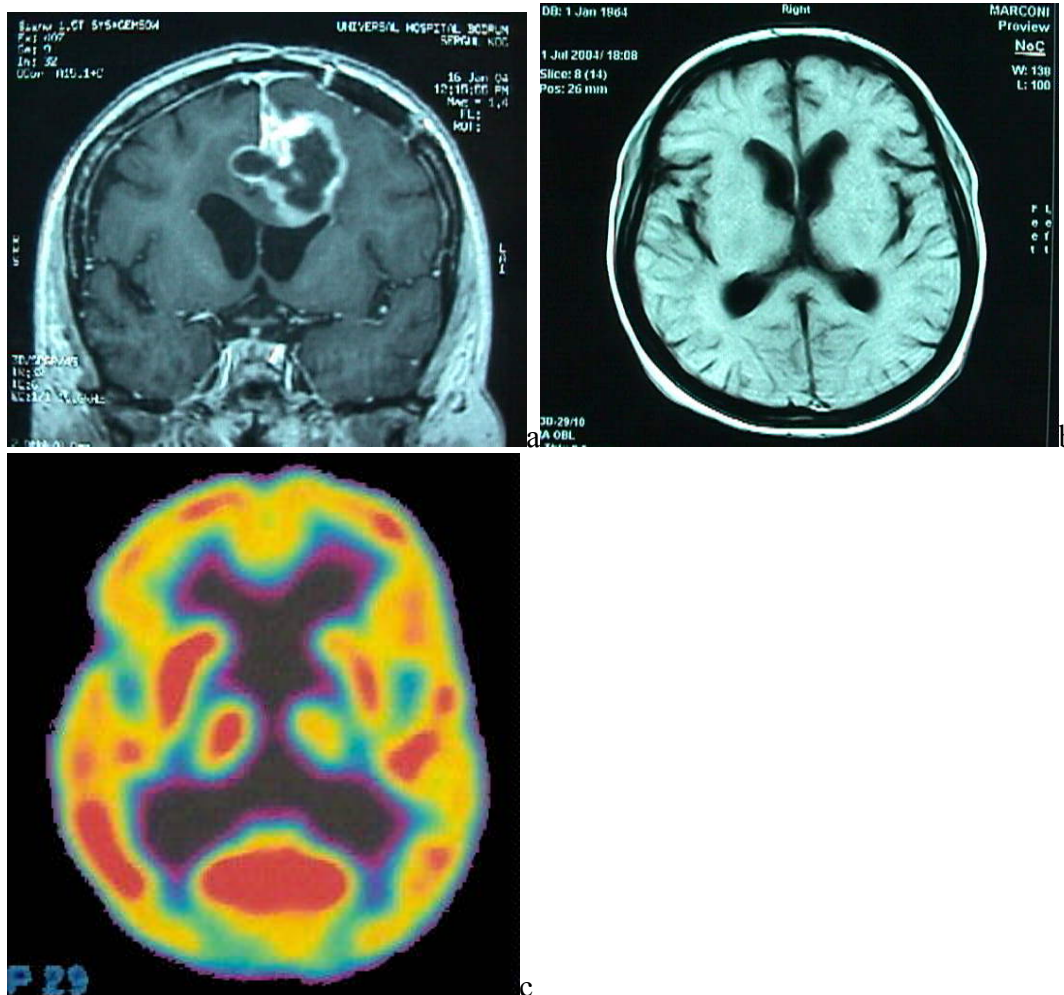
a Bi-frontal typical GBM on MRI, b after treatment 4 years later, and c a recent PET-CT brain scan of same LTGBMS case, who is still alive without any treatment.
